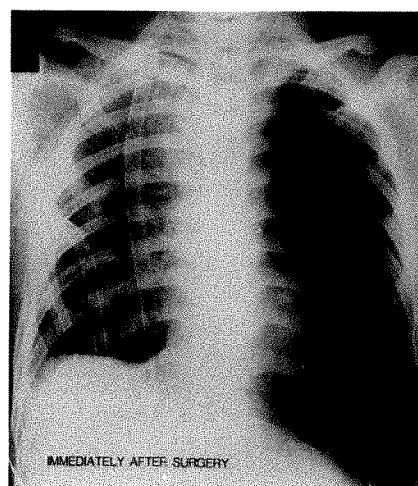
Chest roentgenogram immediately after the surgery showing unilateral pulmonary edema.
